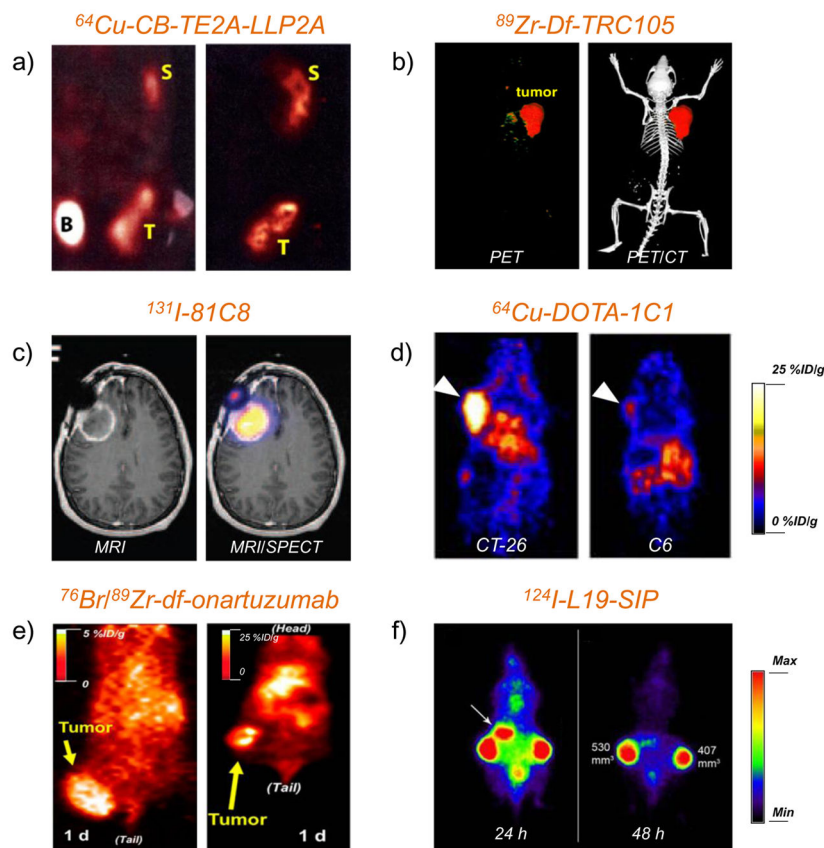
PET or SPECT imaging of vascular targets in cancer models
